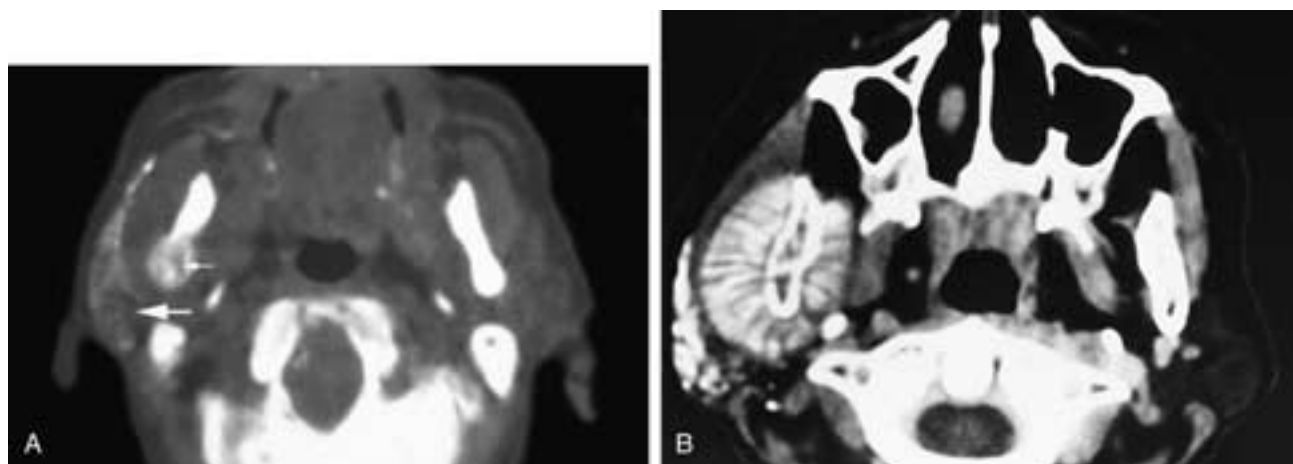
Axial CT-sialogram scan (A) shows an invasive tumor of the right parotid gland (*large arrow*) and a destructive lesion of the posterior right mandible (*small arrow*). This patient had metastatic lung carcinoma. Axial CT-sialogram scan (B) shows a normal contrast-filled right parotid gland. The right mandible is expanded by a lesion that causes an aggressive periosteal reaction. The resulting mass was clinically interpreted as a parotid tumor. This patient had a plasmacytoma.
